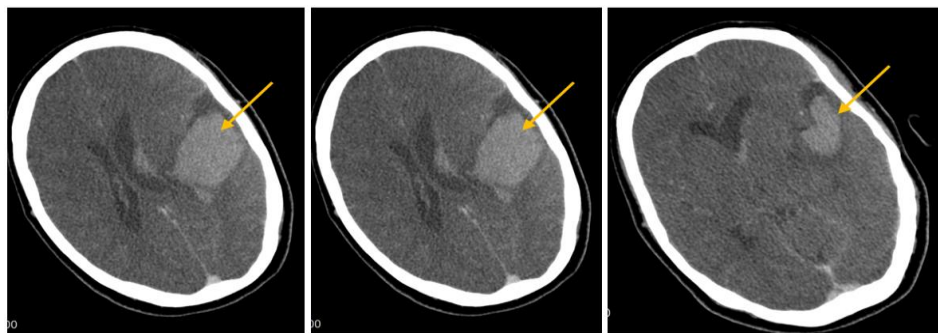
Cerebral CT scan in axial section show a left parietal-temporal intra parenchymal hematoma with compression and subfalcine cerebral herniation
